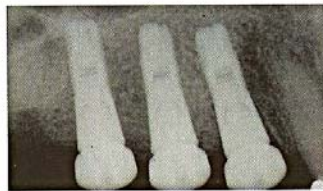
Radiograph immediately after the insertion of three 4.5 x 11.0 mm ST fixtures. Note: immediate fixture at site #5 and localized osteotome sinus floor elevation at site #3.
